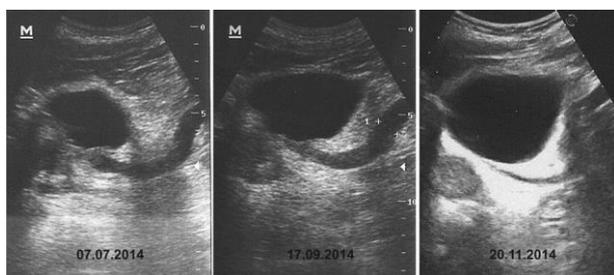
Dynamics of ultrasound in stage IV cancer during immunotherapy
